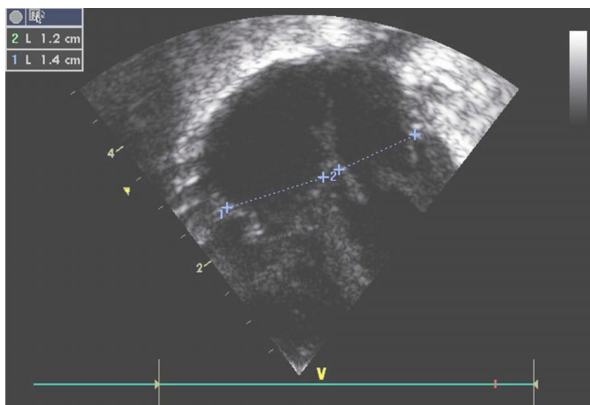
ECHO; Apical 4 chamber view showing dilated chambers with reduced ventricle function.
